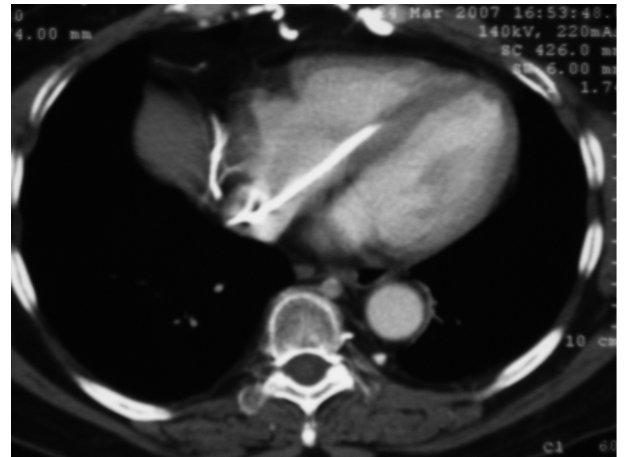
CT angiography showing the absence of filling in the superior vena cava and collateral filling.
